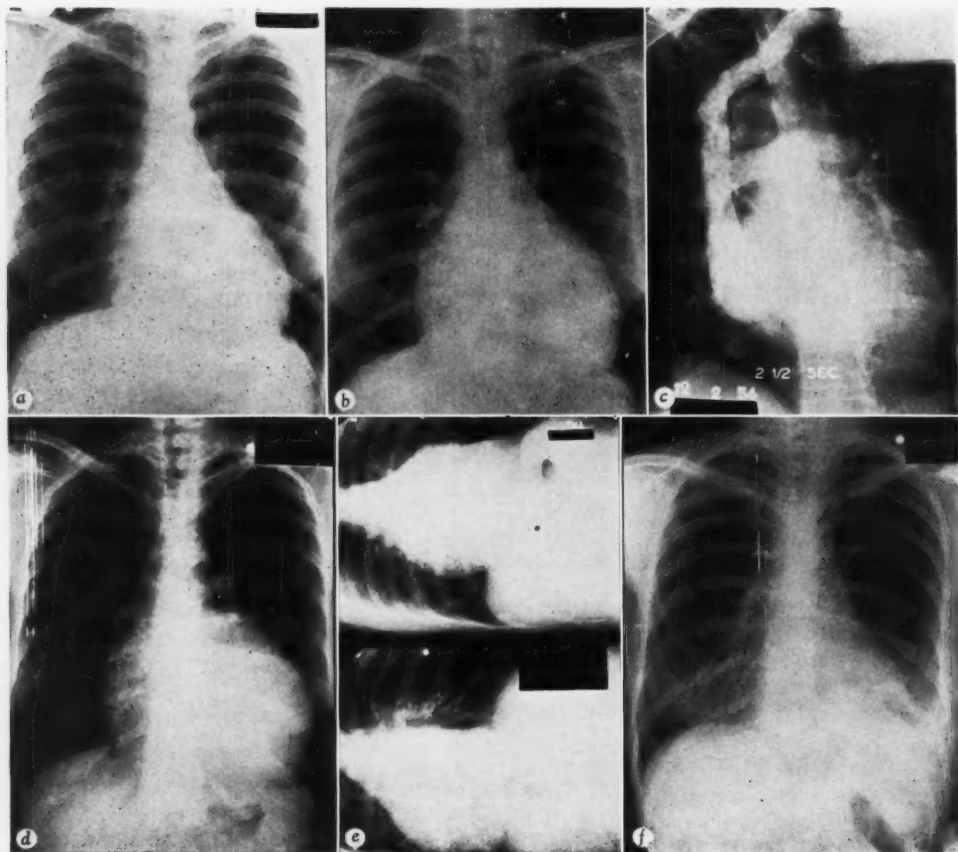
Case 1. *a.* Enlargement of cardiac shadow in 1952. *b.* Further increase in size of cardiac shadow 2 years later. *c.* Angiocardiogram showing normal right atrial contour and demonstrating that enlargement of the cardiac shadow is caused by pericardial effusion or thickened pericardium. *d* and *e.* Roentgenograms taken in erect and lateral decubitus positions after removal of 80 ml. of pericardial fluid and replacement by air. *f.* Postoperative appearance, showing normal size of cardiac shadow.
